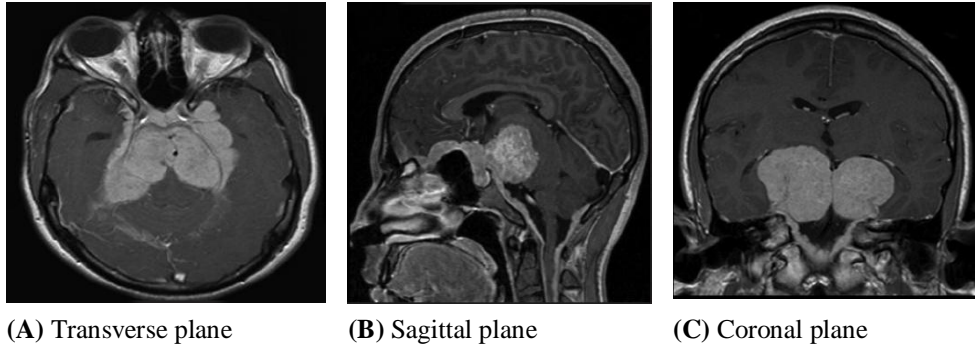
Brain MRI images of three planes
